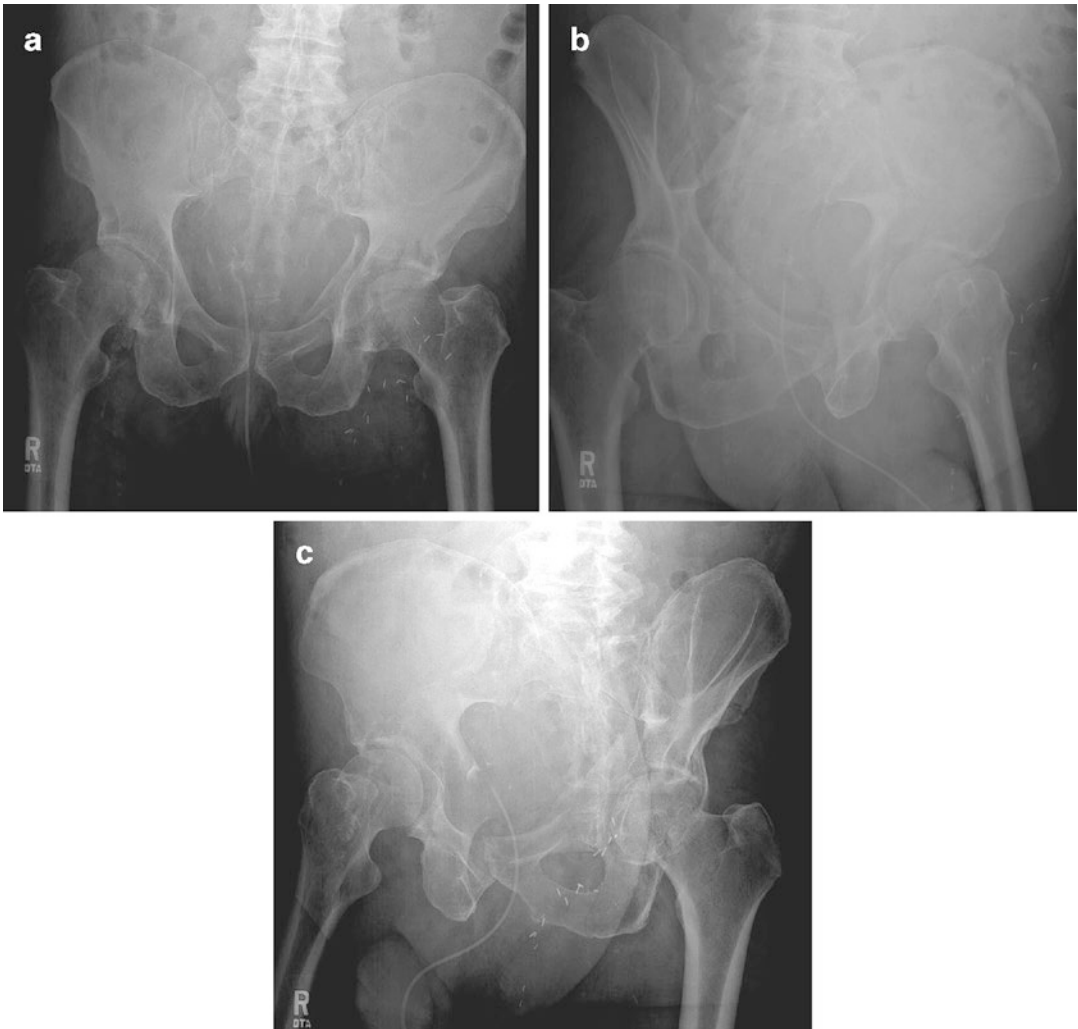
(a) AP radiograph pelvis. (b) Iliac oblique radiograph pelvis. (c) Obturator oblique radiograph pelvis
